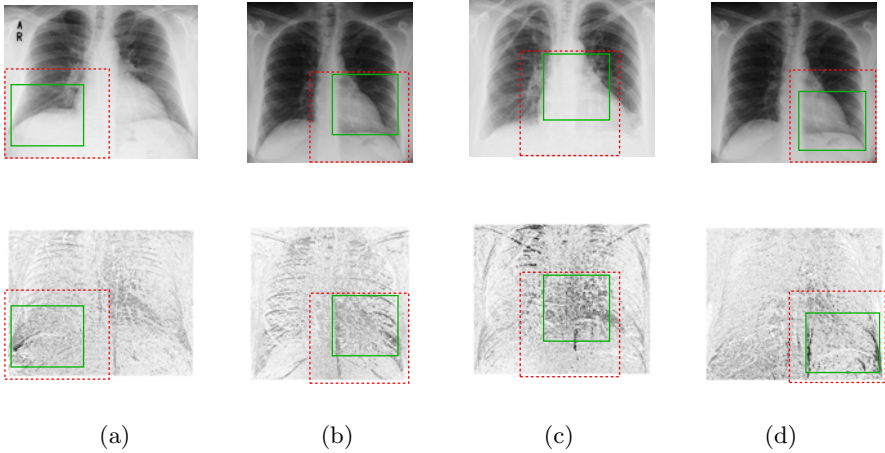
Frontal chest x-ray images, top row shows the ROI detection overlaid on the original image and bottom row shows the corresponding relevance map. Global ROI is shown in red and the refined ROI in green. The pathologies are (a) right pleural effusion, (b) enlarged heart shadow, (c) enlarged mediastinum and (d) left pleural effusion.
